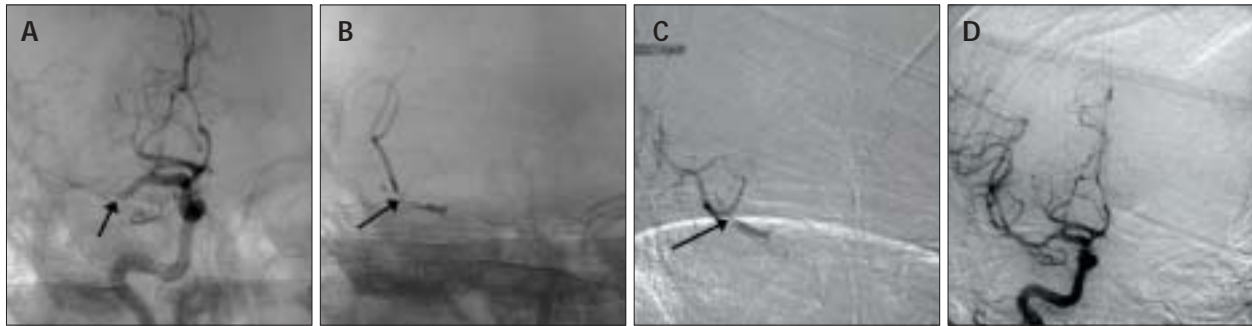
A recanalization sequence using the MicroLysis Catheter. A pretreatment angiogram. The arrow points to occlusion (A). Fifteen minutes of ultrasound with concurrent intra-arterial infusion of 6 mg tPA (B). Thirty minutes of ultrasound with concurrent intra-arterial infusion of 10.5 mg tPA (C). Sixty minutes of ultrasound with concurrent intra-arterial infusion of 20 mg tPA (D).
